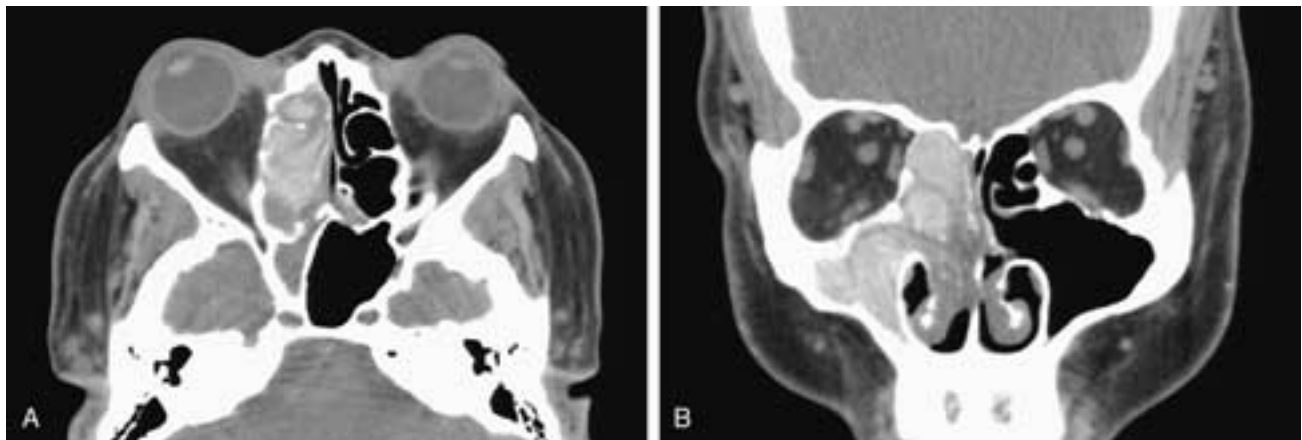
Axial (A) and coronal (B) CT scans show opacification of the right ethmoid, sphenoid, and maxillary sinuses. Within the ethmoid and maxillary sinuses are polypoid areas of higher attenuation representing desiccated secretions within chronic polyps. This patient had no history of allergies. Note that the left-sided sinuses are virtually normal.
